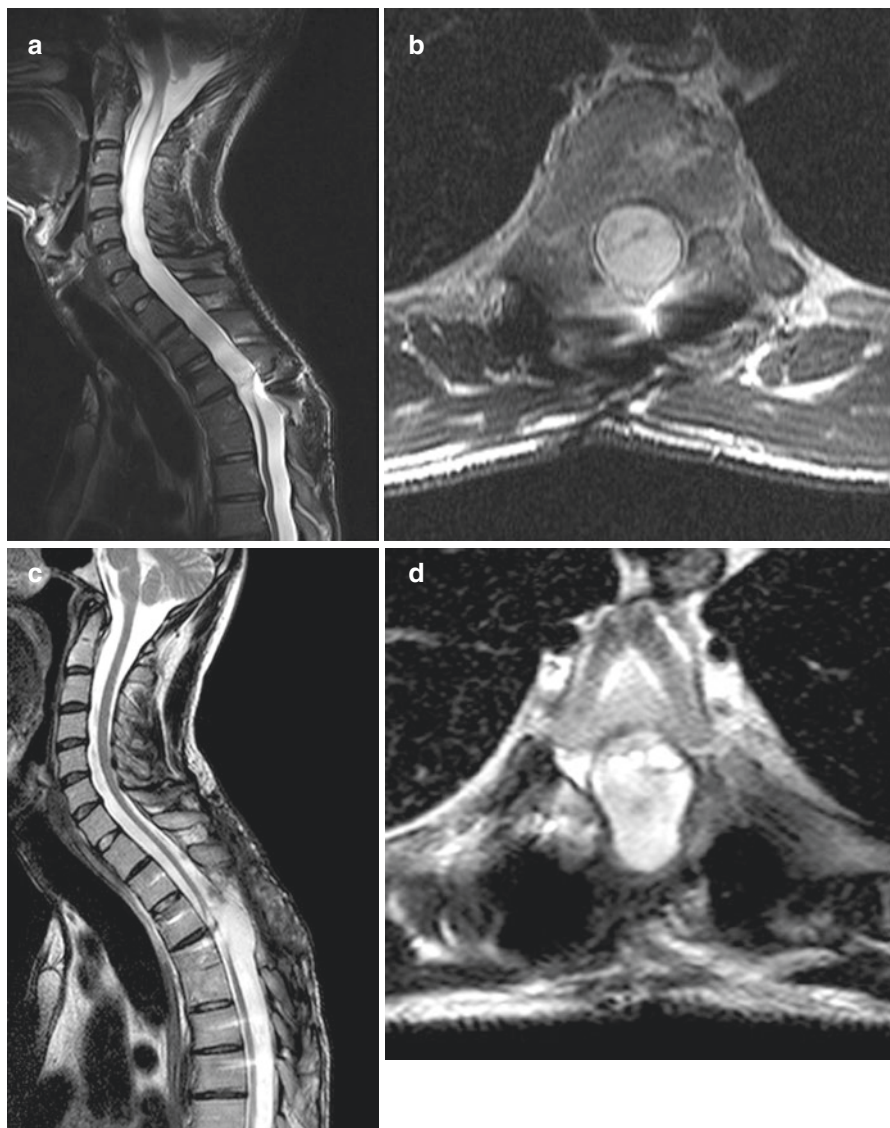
(a) T2-weighted MRI scan of a 28-year-old man 6 years after an accident with fracture at Th4 and a complete spinal cord lesion. A huge syrinx has formed from C1 to Th4. (b) The axial scan at Th4 demonstrates the compression of the cord from posterior. After arachnolysis and duraplasty at Th4, the postoperative sagittal (c) and axial (d) scans show the complete collapse of the syrinx and the free CSF pathway at the injury level
